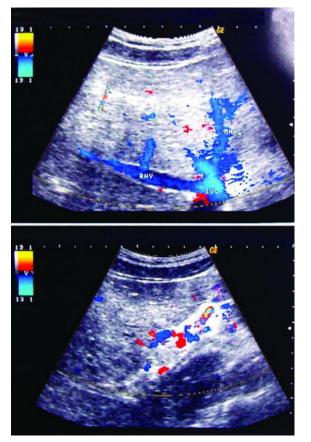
Splenic vein thrombosis and partial recanalization on Doppler sonography of the hepatic and splenic veins
